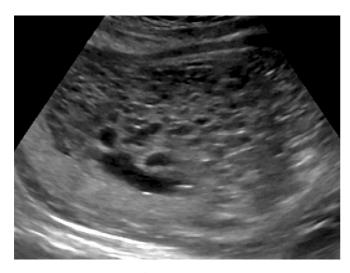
From Figure 35.1 of Scoutt LM, Hamper UM, Angtuaco L, eds. *Ultrasound*. Oxford, UK: Oxford University Press; 2017.
